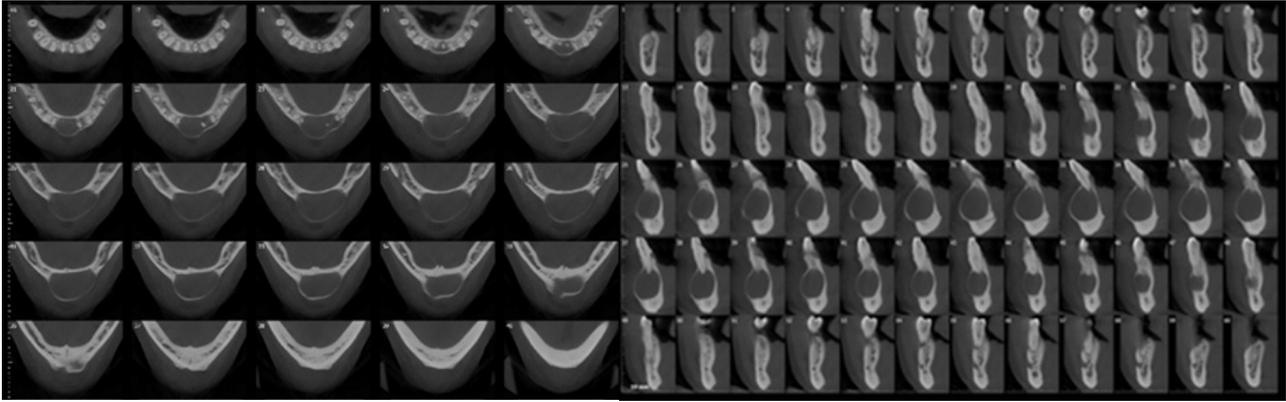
Preoperative cross-sectional and axial CBCT scans showing expansion and perforation of the buccal cortex.
